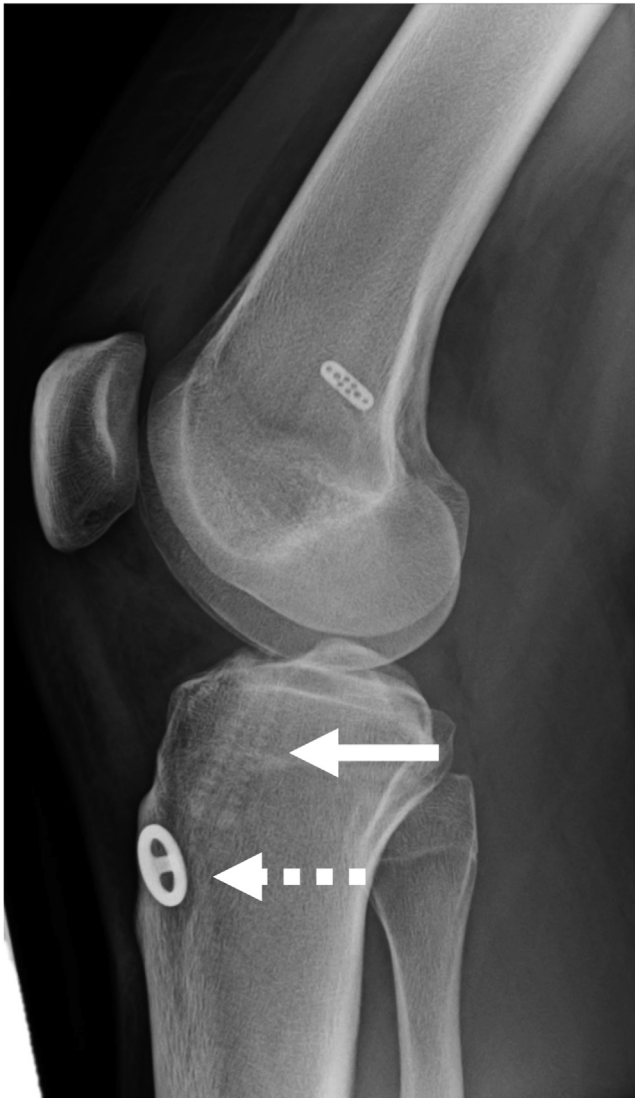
Lateral postoperative radiograph showing the final construct with interference screw (solid arrow) and extracortical button (dashed arrow).
